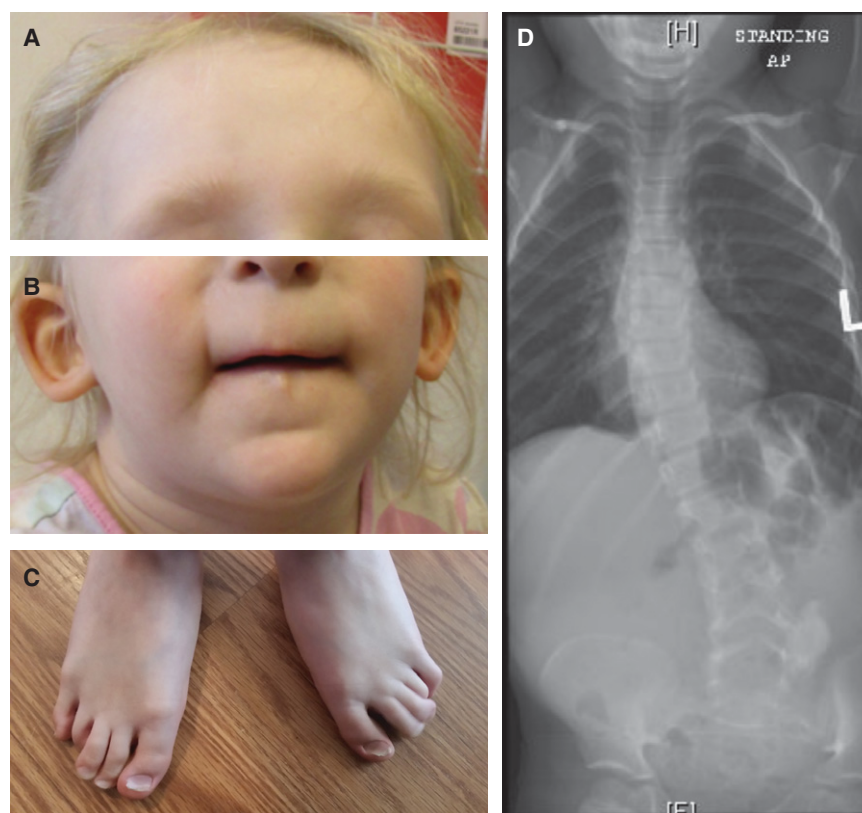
Clinical features. (A) Sparse scalp hair with receding frontotemporal hairline and thin eyebrows. (B) Protruding ears, thin upper lip, long flat philtrum, and horizontal groove on chin. (C) Clinodactyly and hammer toes. (D) Scoliosis radiograph.
